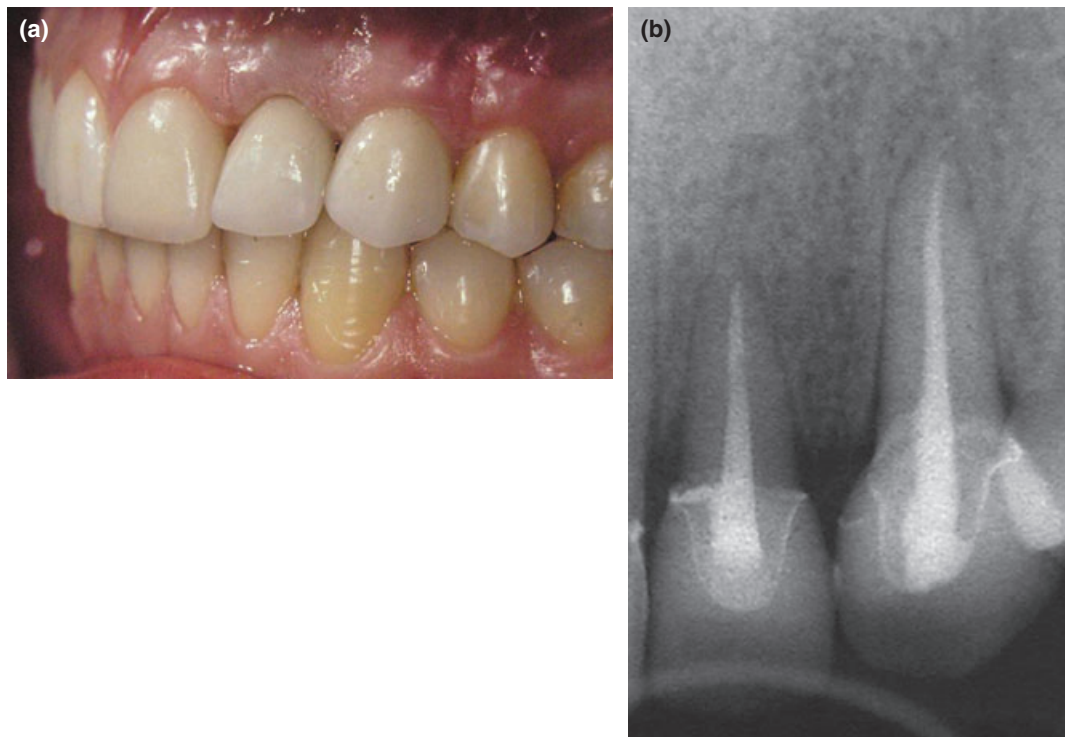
(a) Empress complete crowns and laminate veneer *in situ*. (b) Radiographic view after cementation of the crowns.
